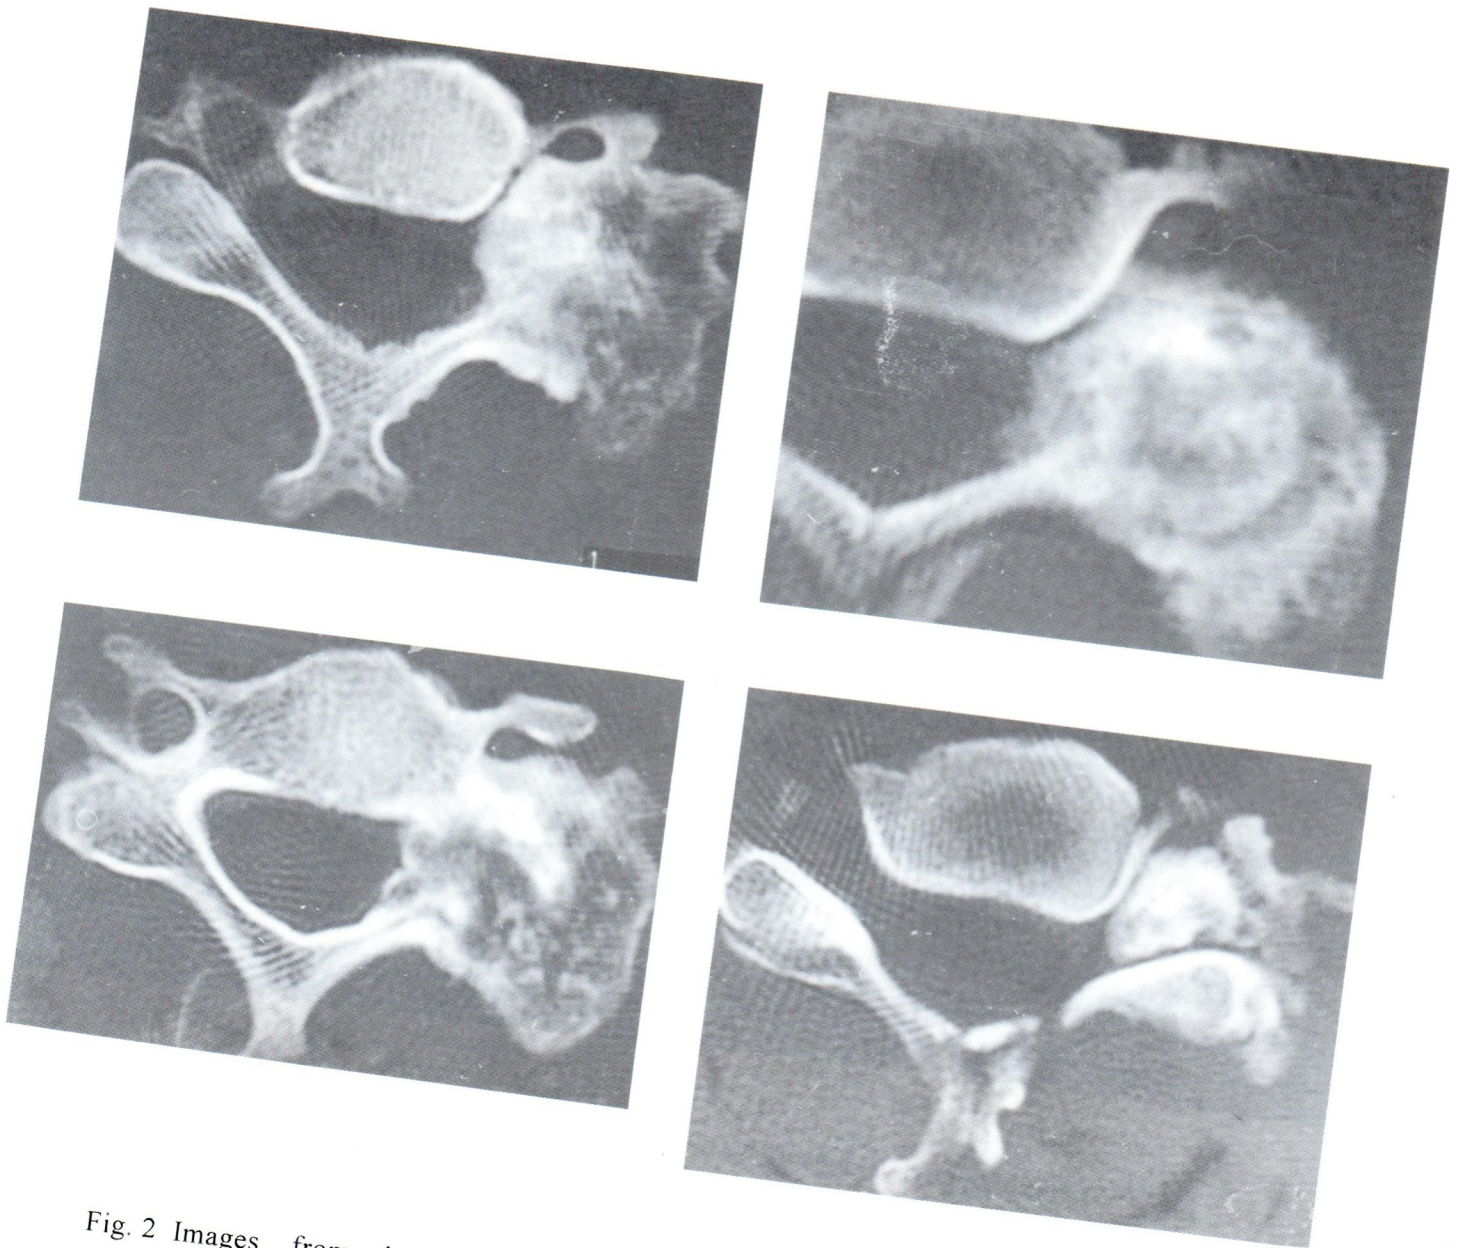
Images from the CT scan gave clearer information, that the lesion had expanded the involved left lateral arch, osteolytic background, calcified matrix and involvement of the left lateral recess and the central canal.
